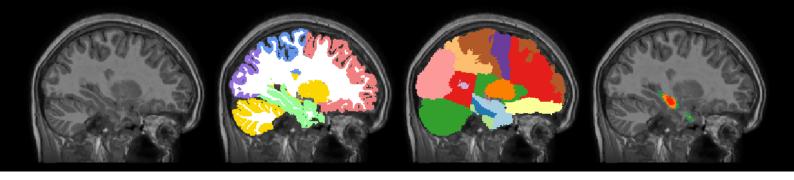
Sagittal slice of a T1-weighted MRI from a TLE patient with segmentation, ROIs and atrophy maps (left to right) as presented by Neurocloud-VOL
